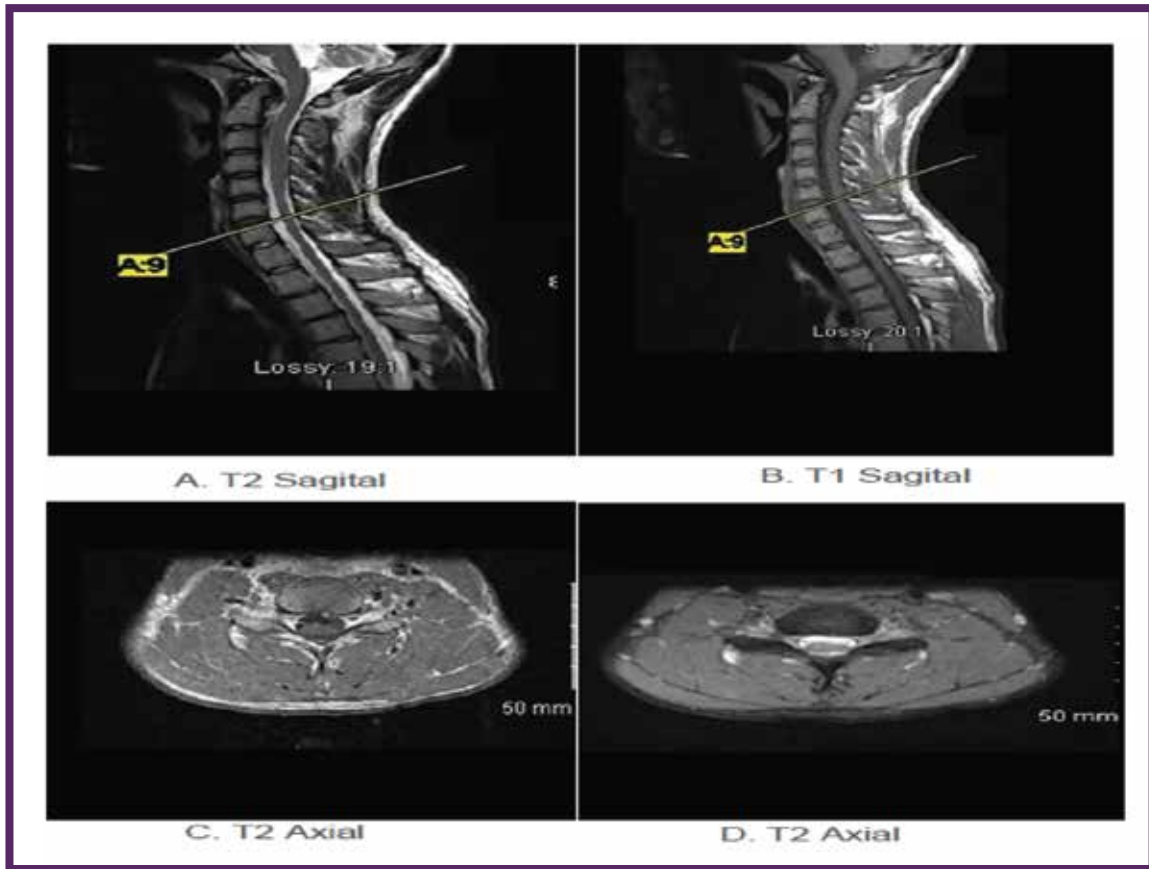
MRI of cervical spine
